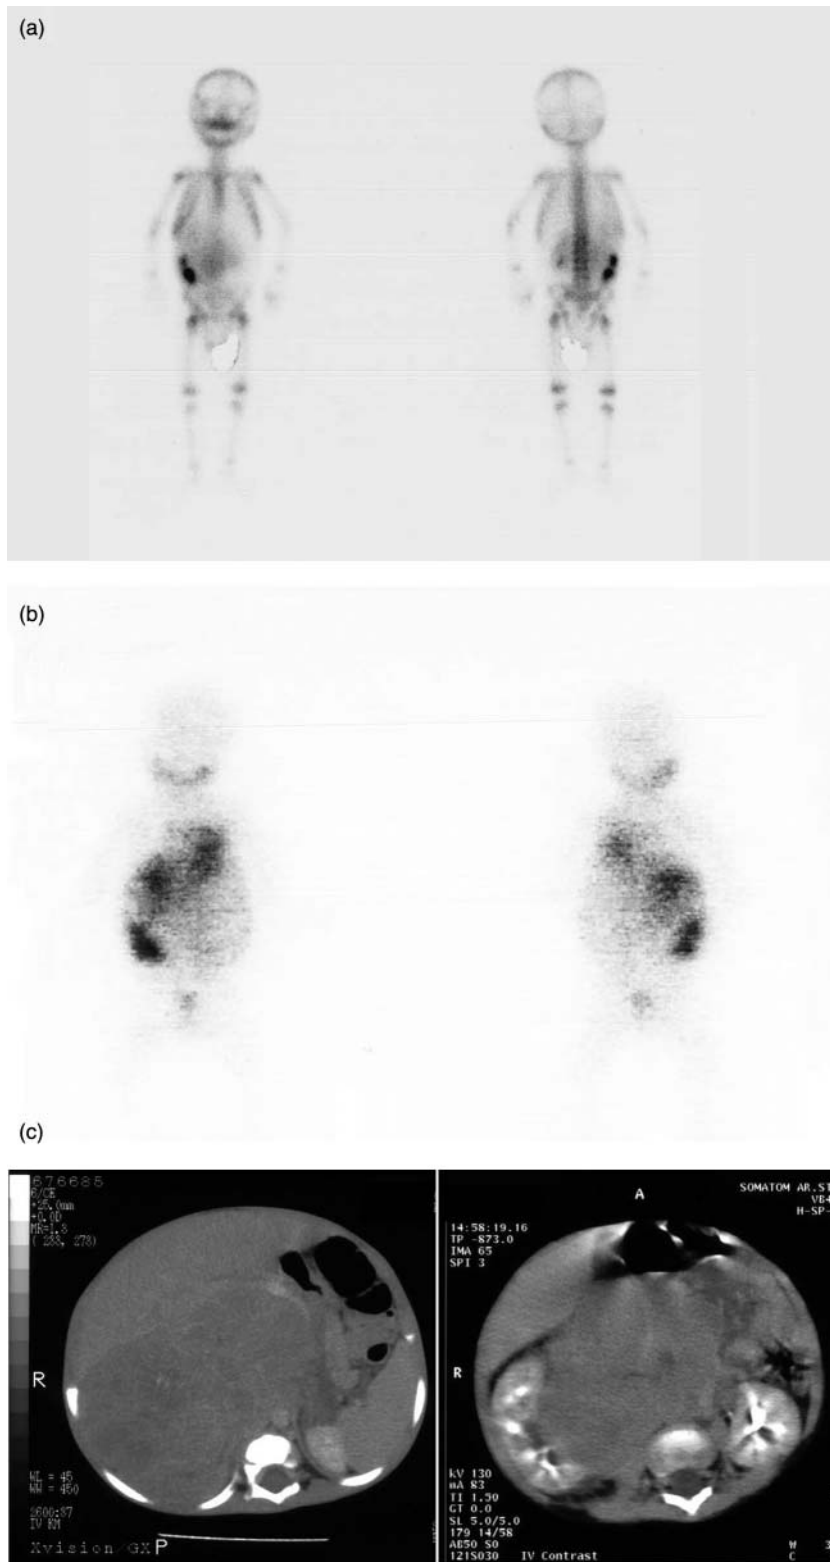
(A) An intra-abdominal mass. A 15-month-old male patient with palpable abdominal mass and in the anteroposterior whole body bone scintigraphy of the patient the mass accumulates Tc-99m methylenediphosphonate. (B) Anteroposterior whole body 24th hour metaiodobenzylguanidine scintigraphy showing the increased activity accumulation in the mass of the same patient. (C) Transaxial CT images corresponding to the mass (left) and kidneys (right) projection, respectively.
